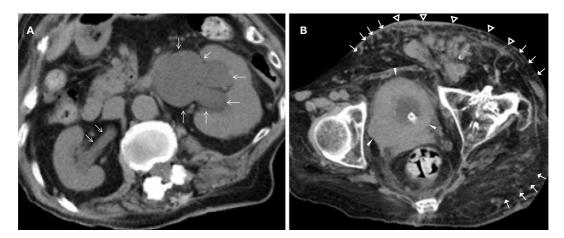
Simple computed tomography of the abdomen and pelvis on admission. (A) The renal pelvises were dilated (arrows), predominantly on the left side. (B) Generalized thickening of the bladder wall (closed arrowheads) and bladder balloon catheterization were observed. Subcutaneous structures of irregular size and form (open arrowheads) and marked subcutaneous edematous changes (closed arrows) were seen in the left pelvis, inguinal area, buttocks, and thigh.
